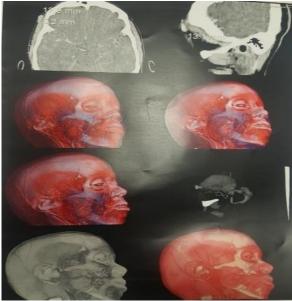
Cerebral CT angio axial section with volume reconstructions showing a right frontal vascular lesion
